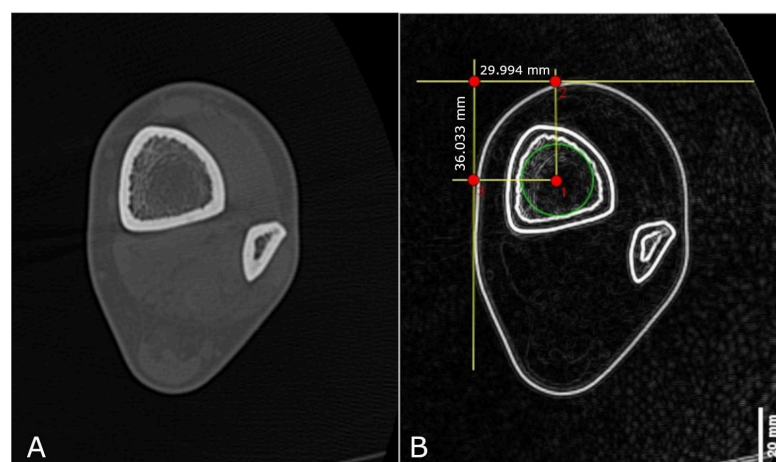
Figure 5. A. CT axial section image of the lower leg located 10mm from the articular surface of the distal tibial epiphysis. B. Image processed with ImageJ, using the “find edges” function to highlight the edges of interest. The green circle delineates the medullary canal, and distances were measured from its center to the maximum points on the X and Y axes
